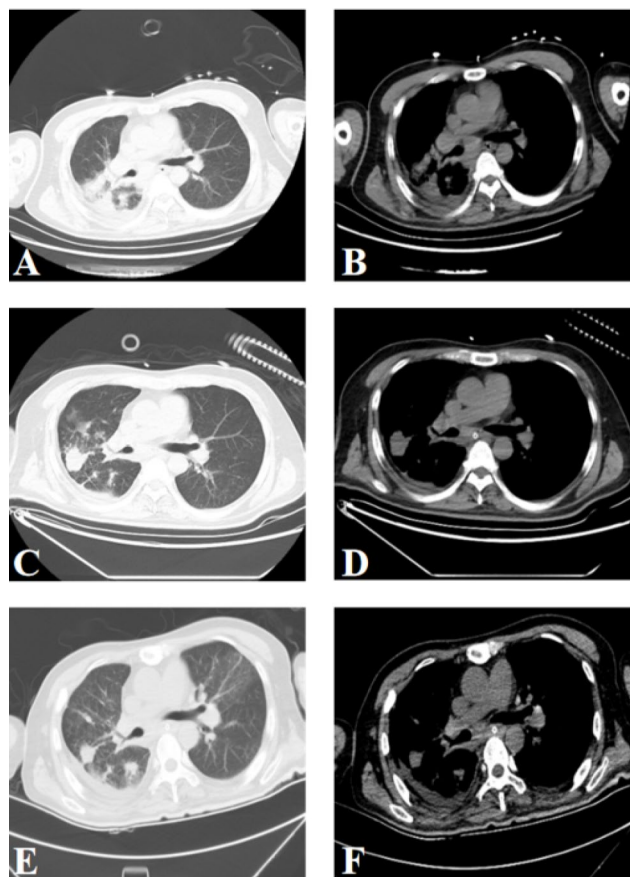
Chest CT image showing the occupation of the right hilar and right middle and lower lobes of the lungs (A, B). After one cycle of chemotherapy, the absorbed of lung lesions became small and aggregated (C, D). After two cycles of chemotherapy, the lung space is reabsorbed to a smaller extent. (E, F)
